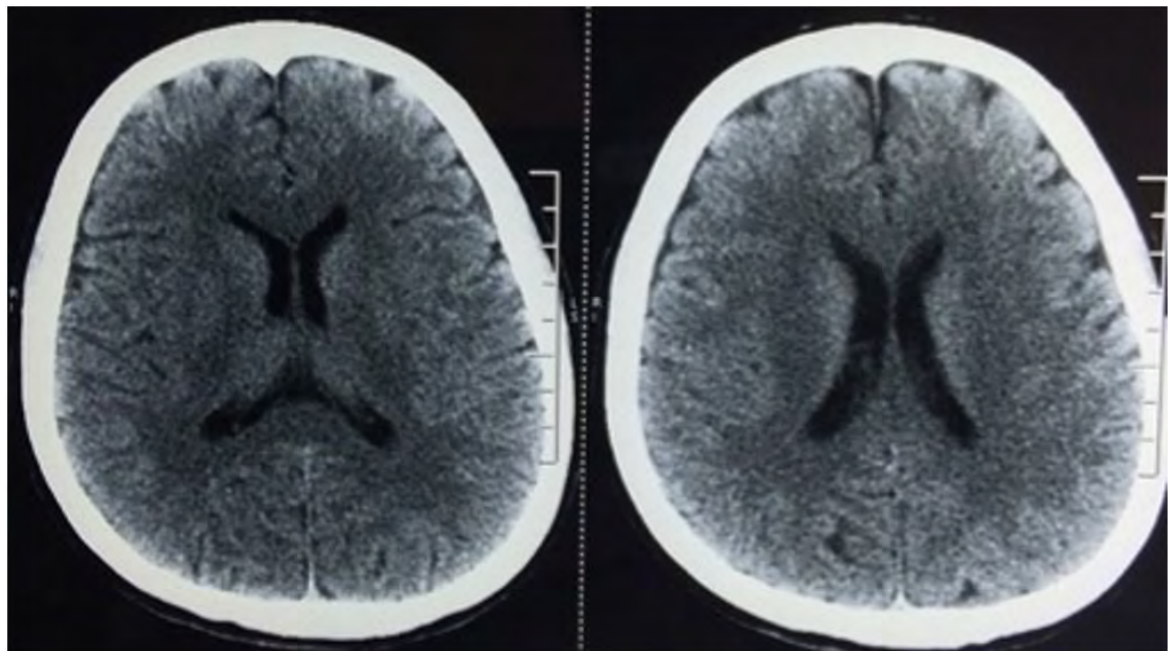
Head CT Scan, without contrast, performed on the 38th post-operative day showing total resolution of the subdural hematoma.
